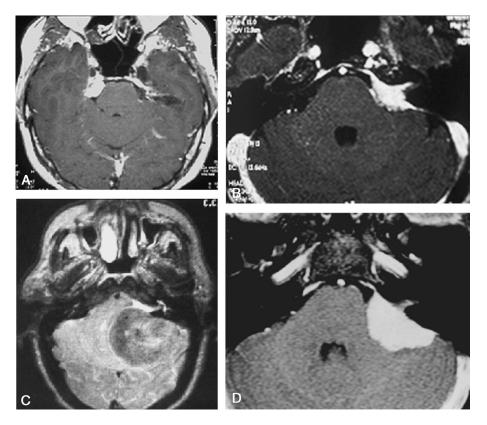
A*, Axial contrast-enhanced T1-weighted MR image showing a small right-sided posterior petrous face meningioma lying anterior to the IAC (Type A). *B*, Axial MRI angiography showing a left-sided posterior petrous face meningioma centered on the IAC (Type M). *C*, Axial T2-weighted MR image showing a slightly hypointense left-sided huge posterior petrous face meningioma lying posterior to the IAC (Type P). *D*, Axial contrast-enhanced T1-weighted MR image showing a meningioma involving the whole posterior surface of the right temporal bone (Type AMP).
